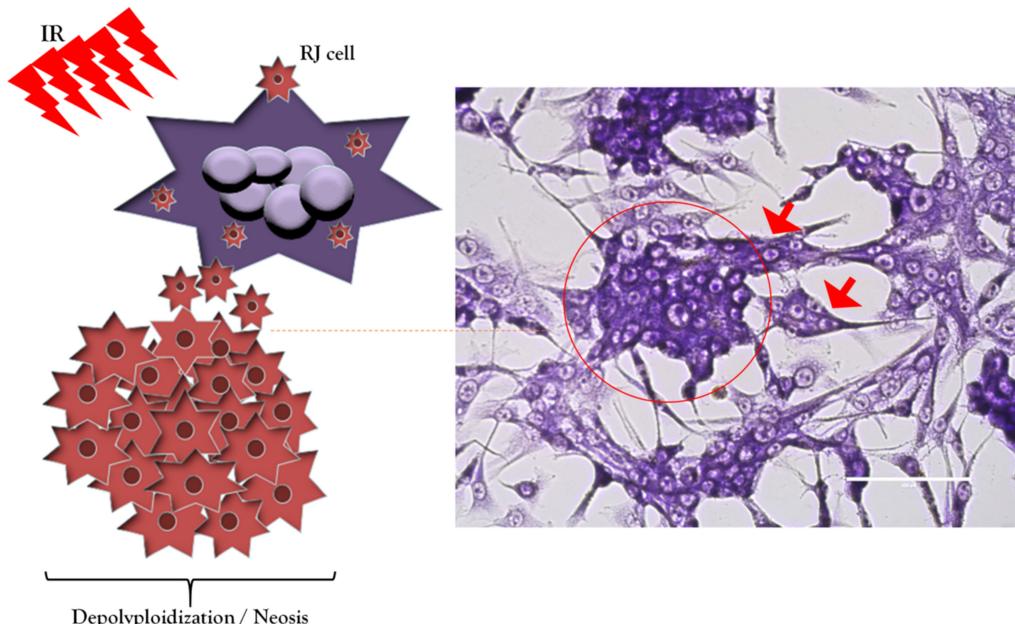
PGCC/MNCG-cell-derived RJ cells in X-ray irradiated GBM U-87 cells.
